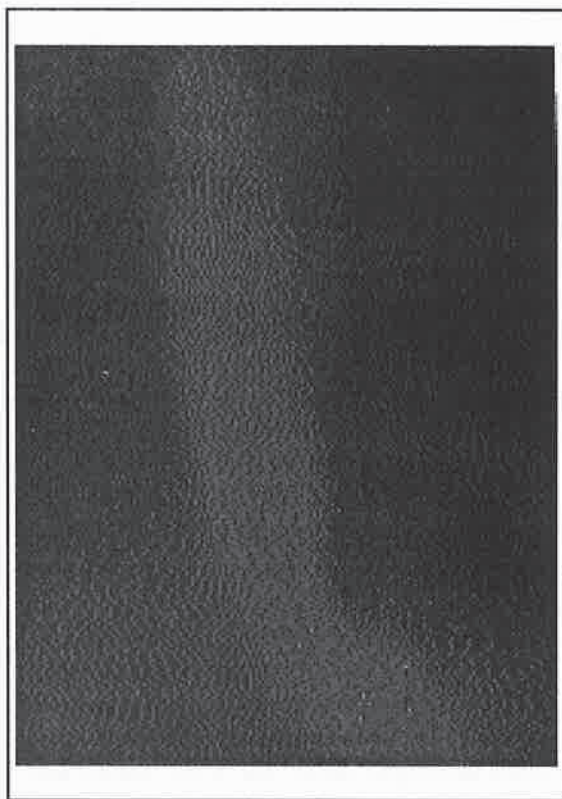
X-rays with barium swallow after esophageal dilatation showed a normal esophagus.
